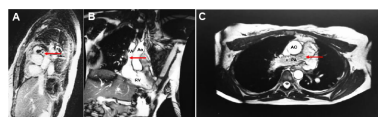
Cardiac MRI revealing mass within right ventricle outflow tract demonstrated by filling defect marked by red arrow: (A) sagittal view (B) coronal view with RVOT and main PA defect. (C) axial view of mass extending into pulmonary arteries (C) [Ao = Aorta; PA = Pulmonary artery; RV = Right ventricle].
